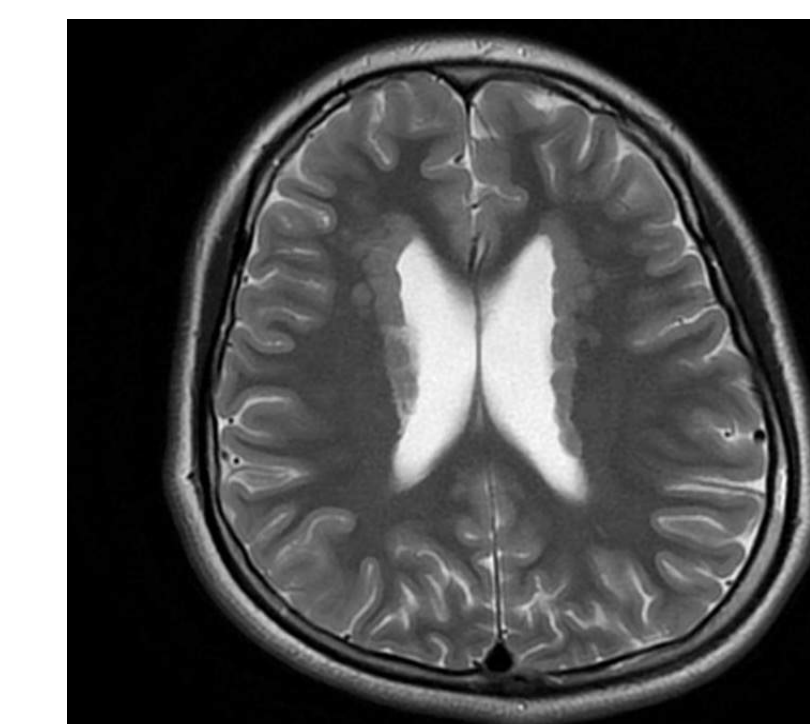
Axial T2 weighted brain magnetic resonance imaging showing grey matter nodules along the surface of the lateral ventricles.
